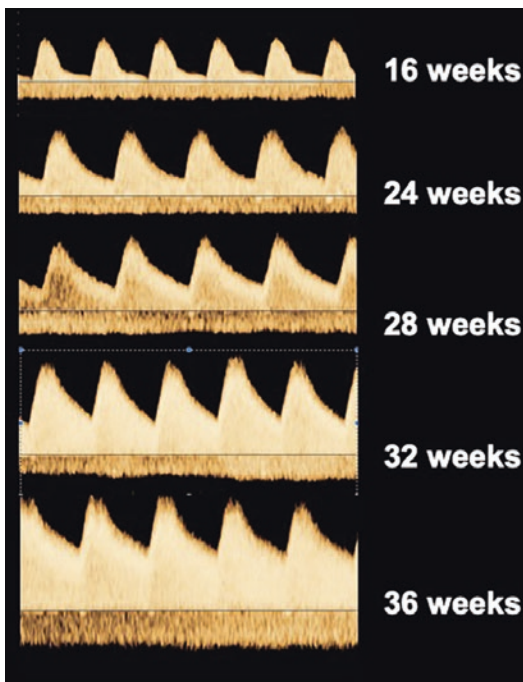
Gestational age effect on the umbilical arterial Doppler waveforms. Panels are organized from top to the bottom according to the advancing gestation. Note the progressive increase in end-diastolic velocity and the concomitant fall in pulsatility as the gestation advances
